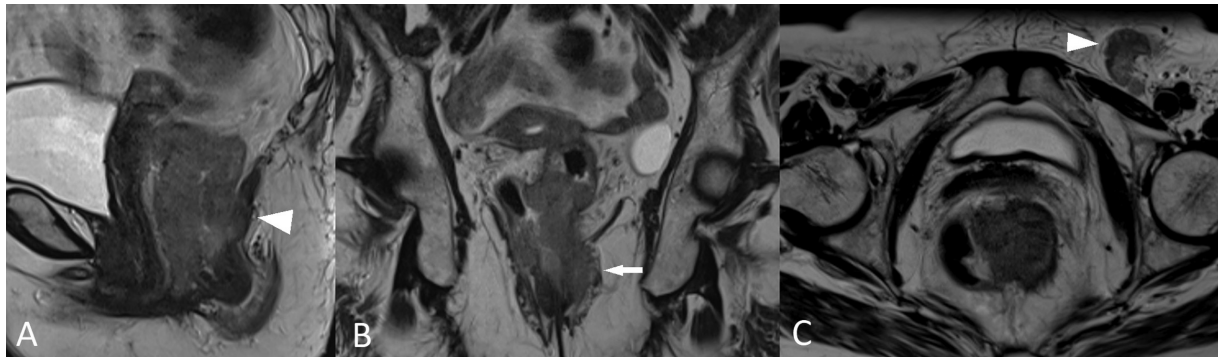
(A–C) Staging magnetic resonance imaging T2-weighted high-resolution images of a biopsy-proven squamous cell carcinoma showing intermediate signal 5.8 cm long tumor infiltrating puborectalis (arrowhead in A) and left side of the anal sphincter below the dentate line (arrow in B), and left inguinal node metastases (arrowhead in C). This tumor was staged as T4b, N2, M0 using a rectal cancer staging system and as T3, N1a, M0 using an anal cancer staging system.
